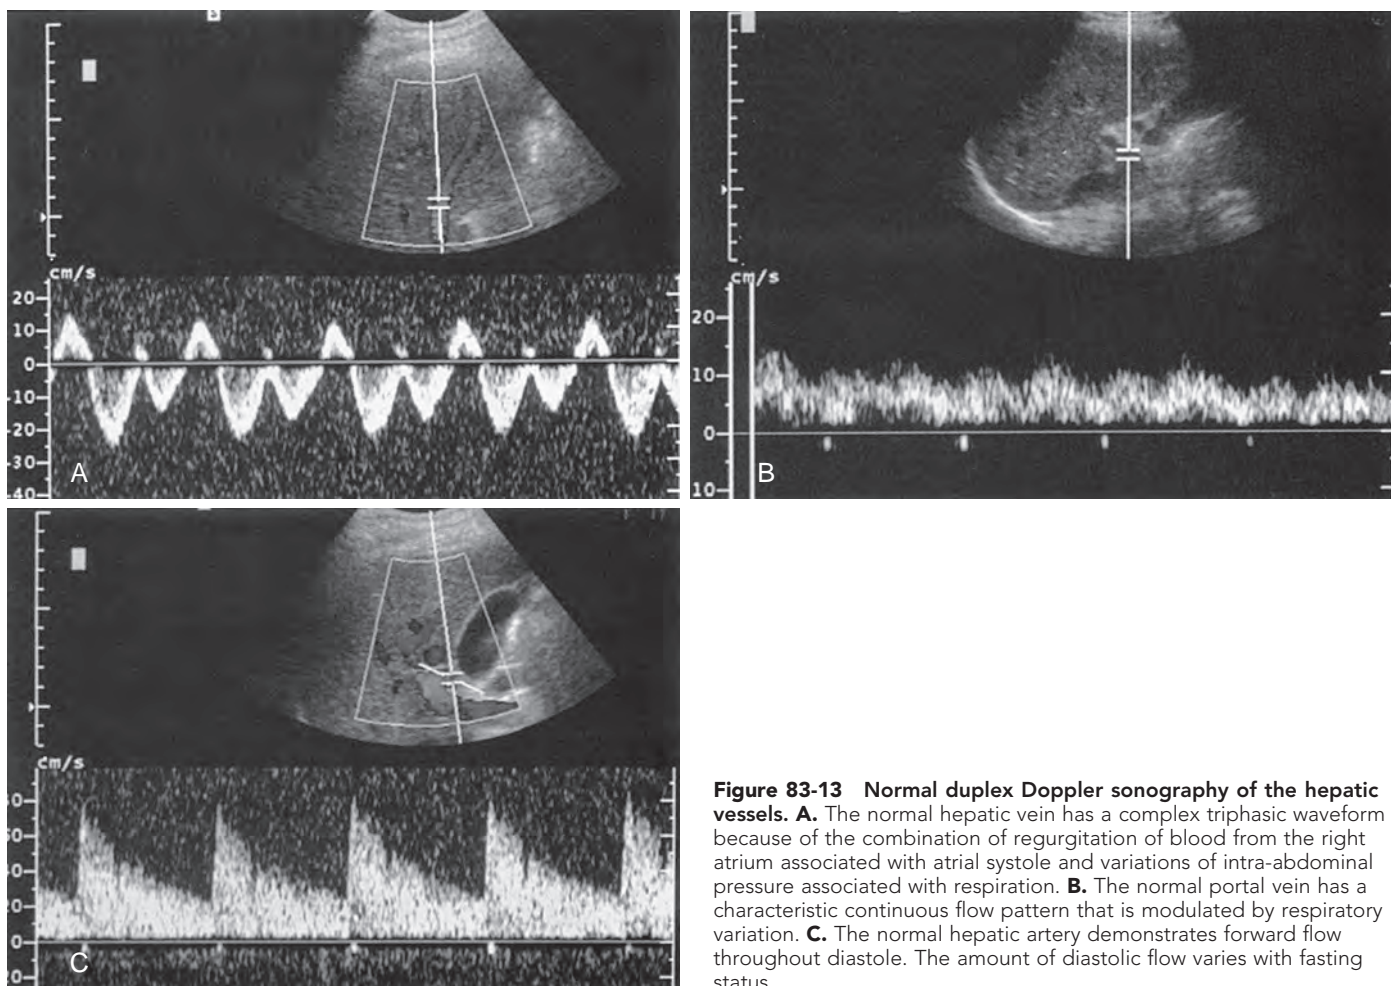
Normal duplex Doppler sonography of the hepatic vessels. A. The normal hepatic vein has a complex triphasic waveform because of the combination of regurgitation of blood from the right atrium associated with atrial systole and variations of intra-abdominal pressure associated with respiration. B. The normal portal vein has a characteristic continuous flow pattern that is modulated by respiratory variation. C. The normal hepatic artery demonstrates forward flow throughout diastole. The amount of diastolic flow varies with fasting status.
